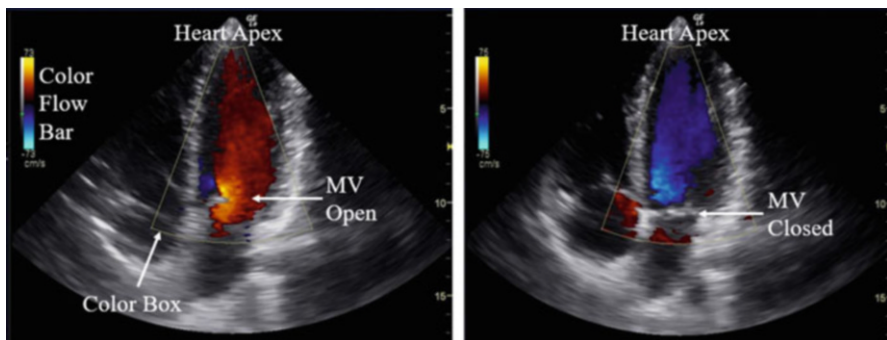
Apical four chamber view with color Doppler in diastole (left panel) and systole (right panel)
